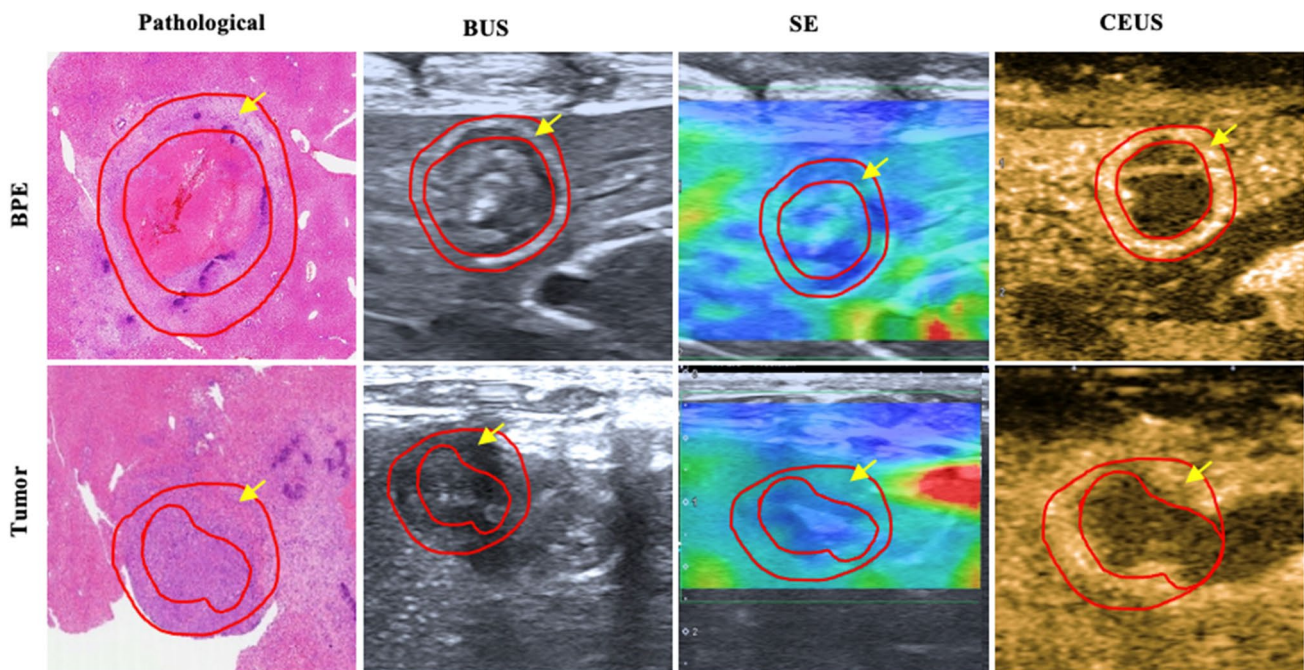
Multi-modality ultrasound images and pathological images of benign periablation enhancement (BPE) and residual tumors after ablation. The middle ring areas surrounded by two red circles (pointed by yellow arrows) are BPE and peripheral residual tumor
